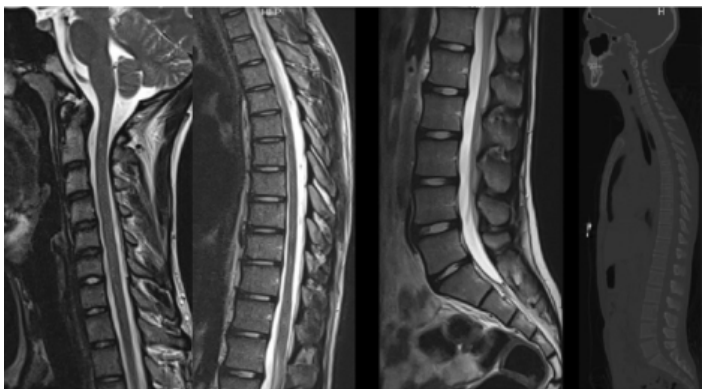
A 16-year-old male patient with generalized paraparesis of the lower extremity (muscle strength 2/5) after traffic accident. Sagittal T2W spinal MRI and sagittal CT images were within normal limits. The patient, who had methylprednisolone and physical therapy, can walk without support after 3 months
